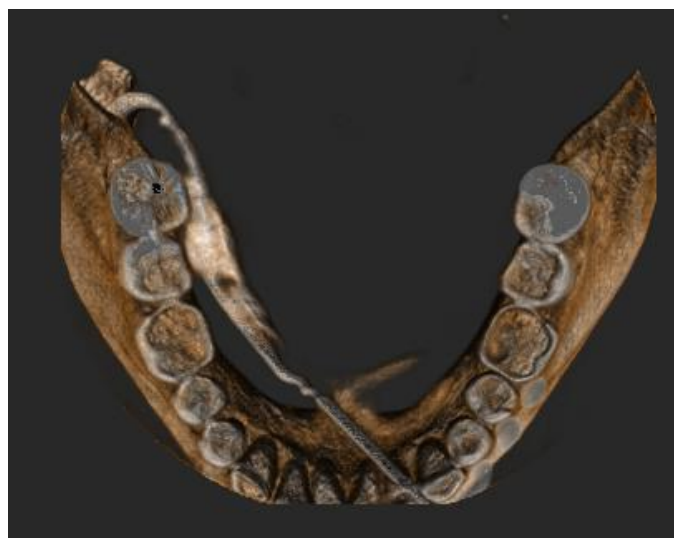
3D image of the CBCT guided sialography of right submandibular gland. The needle of the cannula and the Wharton's duct are clearly visualized in the floor of the mouth. The sialolith can be appreciated in the posteromedial aspect of the mandible
